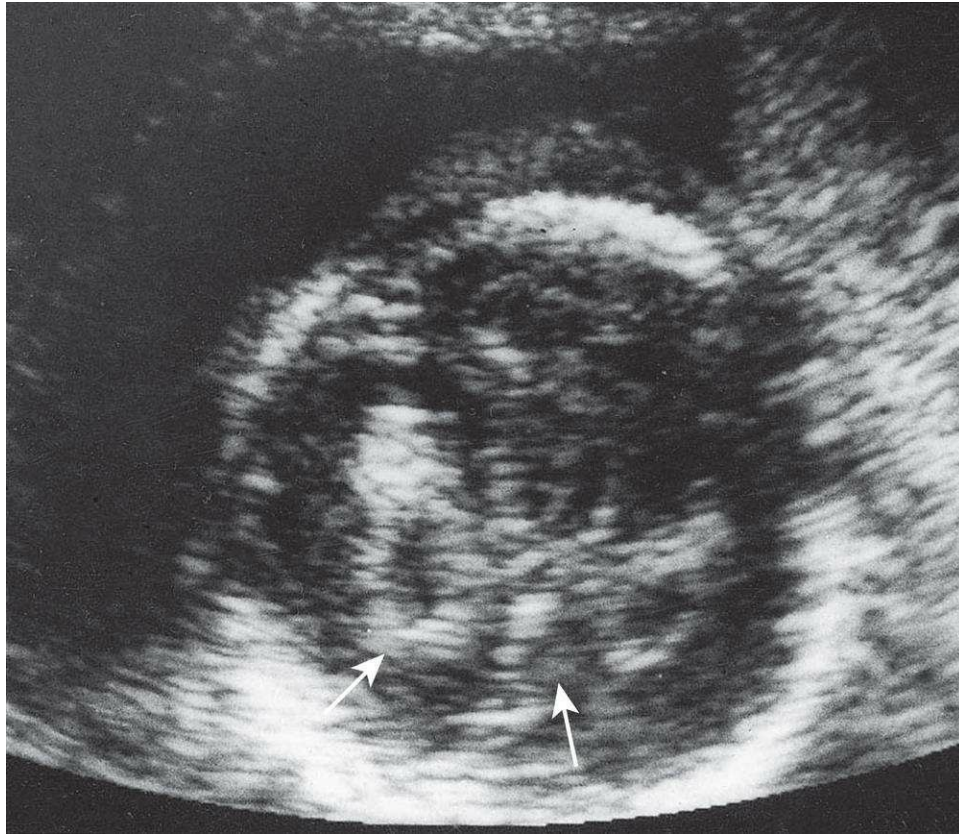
Ultrasonogram of a fetal brain showing bilateral choroid plexus cysts (arrows).
